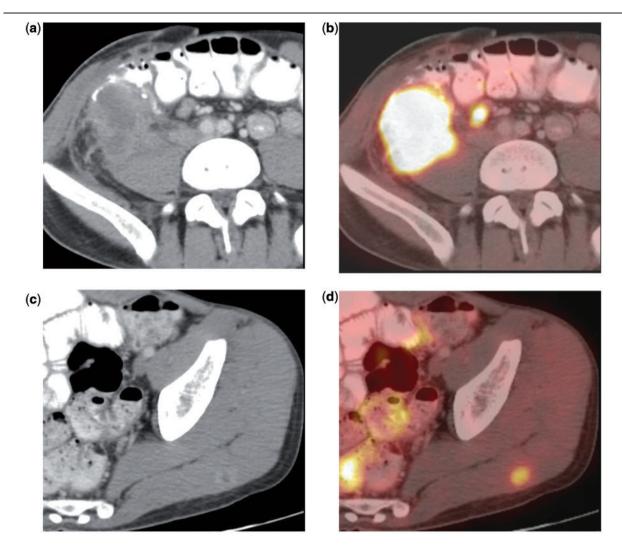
A 62-year-old woman with locally advanced cancer of the right colon. (a, b) CT shows invasion of adjacent structures, which is depicted easily on PET/CT. (c, d) CT reveals a subtle skeletal mass with increased FDG uptake on PET/CT. Discovery of this metastasis led to restaging of the patient.
